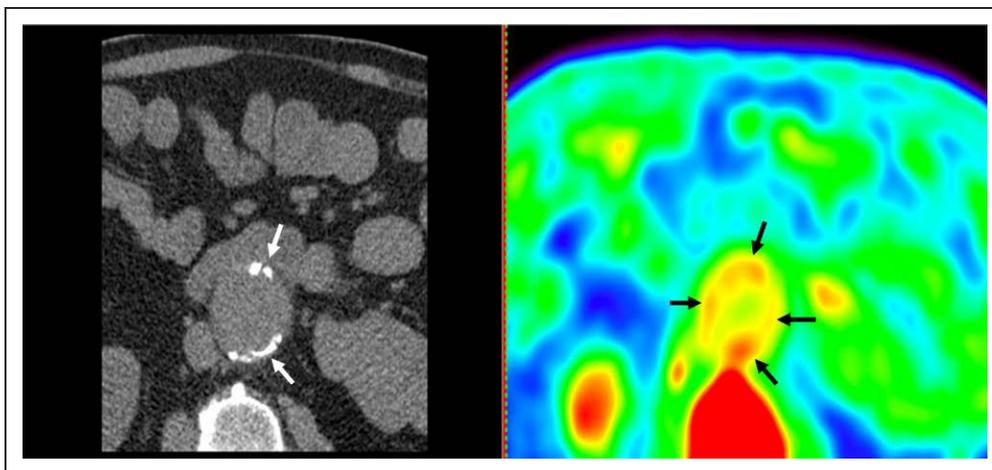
Example of an aneurysm with areas of ^{18}F -NaF uptake (positron emission tomography [PET]-computed tomography [CT], right) that do not correlate with calcification visible on CT (left). On the CT scan, calcification is visible at the anterior and posterior wall of the aorta (white arrows); however, there is almost circumferential ^{18}F -NaF uptake (black arrows). This shows that there are areas where the PET-CT tracers detect active mineralization, where none is detected by CT scan. The signal intensity of ^{18}F -NaF uptake visualized by PET-CT requires a careful quantitative analysis, which includes calculation of tissue-to-background ratios using background blood pool activity in the right atrium. Moreover, manual adjustment of regions of interest is important when analyzing ^{18}F -NaF uptake in structures adjacent to the bone to ensure that any signal attributed to bone is discarded.
